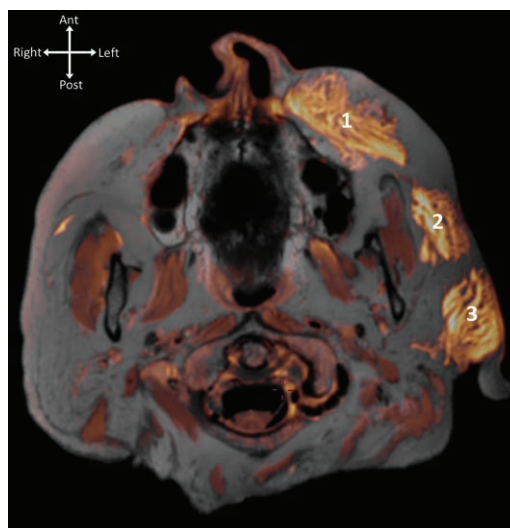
T1 and T2 fused magnetic resonance image in the transverse plane showing the superficial nasolabial fat compartment (1), the middle cheek fat compartment (2), and the lateral cheek fat compartment (3). Note that the transverse section is below the level of the medial cheek fat compartment and above the jowl fat compartment.
